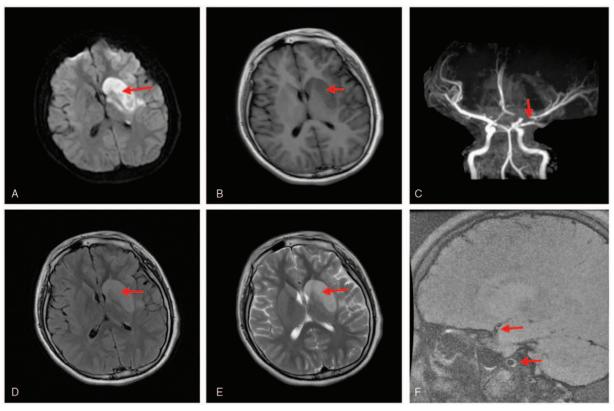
(A, B, D, E) Multiple flake-shaped shadow of longer T1 and T2 signals in the left basal ganglia and frontal-parietal lobes. FLAIR and DWI images showed high signals. (C, F) Multiple segmental severe stenosis at initial segment of the left anterior cerebral artery and M1 proximal segment of the MCA; the initial segment of the right anterior cerebral artery was slightly thinner (red arrow). DWI=diffusion-weighted imaging, FLARE=fluid-attenuated inversion recovery, MCA=middle cerebral artery.
